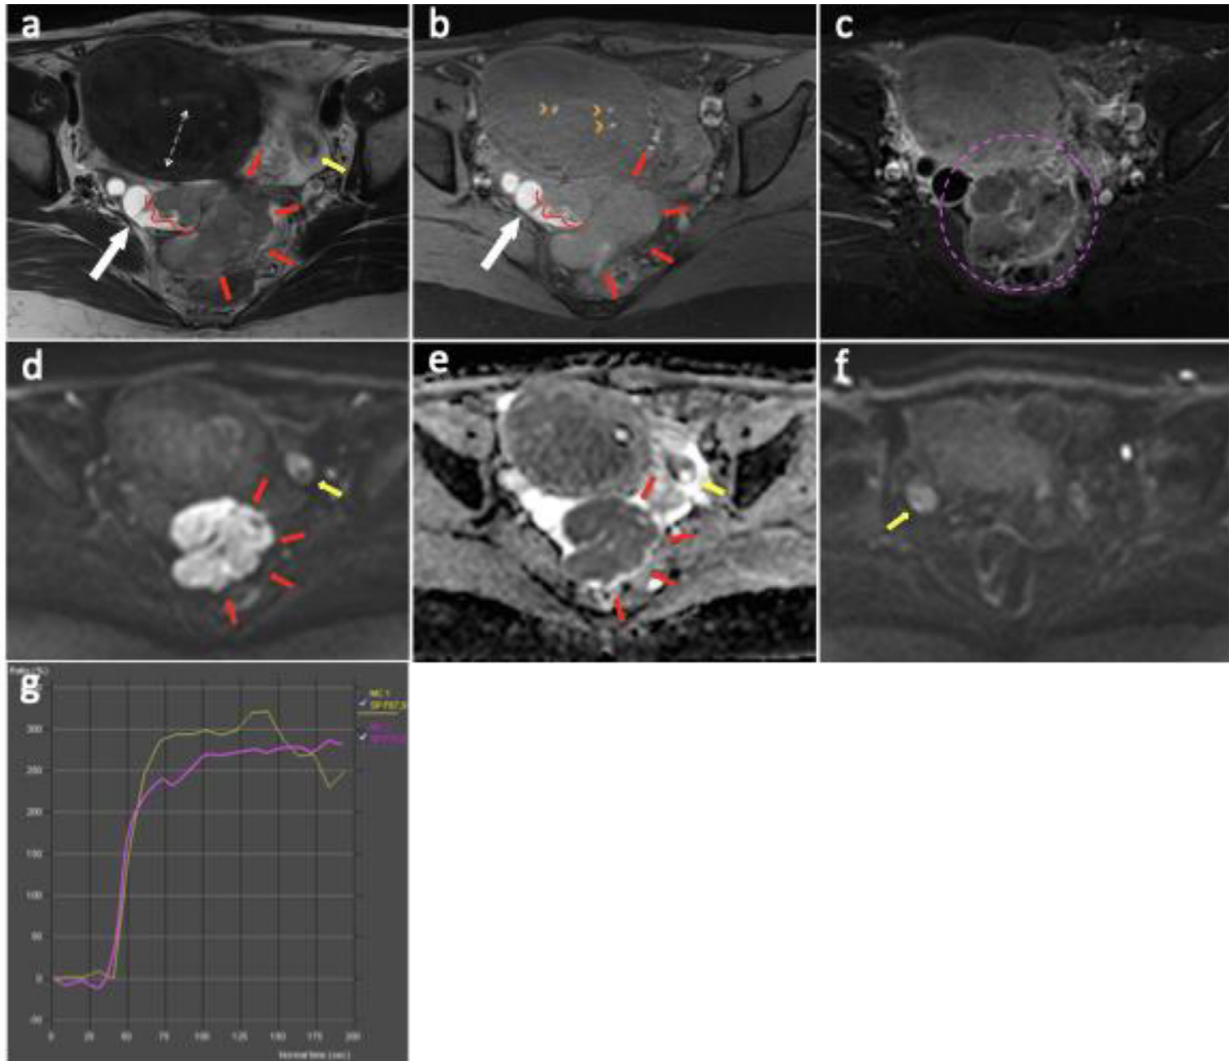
MR axial T2WI (A), T1WI Fat Sat unenhanced (B), DCE-T1WI with digital subtraction (C), synthetic b-1000 DWI (D and F), ADC map (E) and TIC pattern in DCE examination (G). Sausage-shaped tumoral mass (red arrow) in the ampullary segment of the right FT, mildly hyperintense on T2WI, isointense on T1WI, with high signal intensity on DWI and lower ADC map (A-E). Note the irregular margin of intraluminal mass (wavy red line) conspicuous thanks to the concomitant hematosalpinx (white arrow) (A and B). The mass exhibits continuous rim enhancement (pink dashed circle) (D). TIC reveals a high-risk pattern compatible with O-RADS MRI 5 tubal lesion (G). Ovaries (yellow arrow) are clearly identifiable separated from the FT mass (A,D,E,F). Diffuse thickening of the uterus junctional zone (double white dashed arrow) with small cystic images, some of which were hyperintense on T1WI (orange arrow head) reflecting diffuse internal adenomyosis (A and B).
